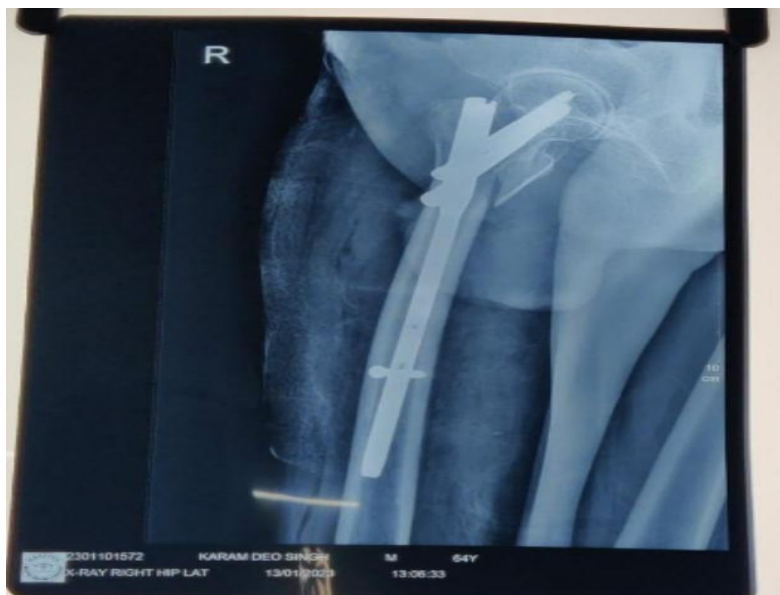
Follow-up radiograph of PFN
